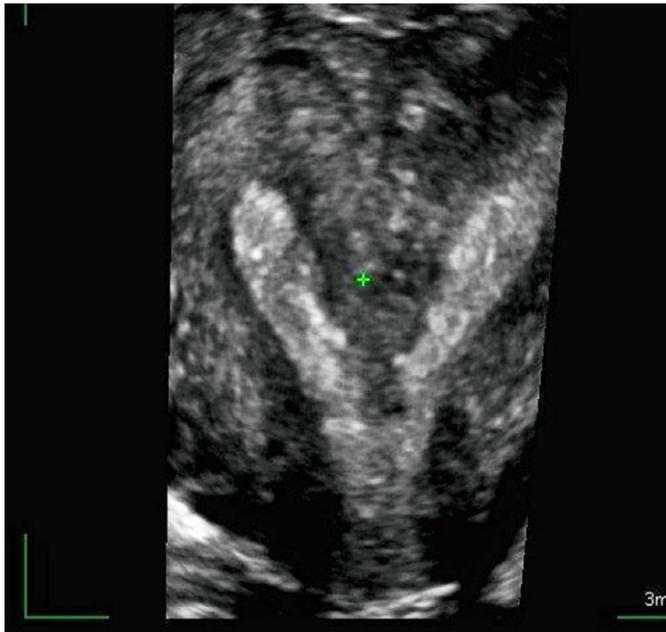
A septate uterus on 3D ultrasound.
